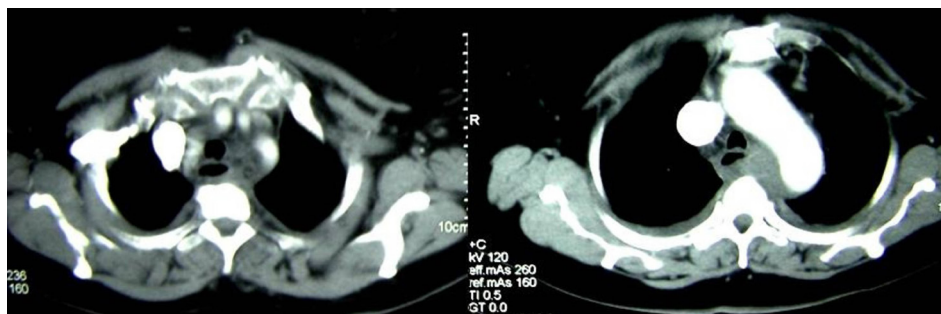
Axial cut of CT thorax on mediastinal window. Abscess with pneumomediastinum in pockets in between left para-oesophageal and left para-aortic region in the upper posterior mediastinum.
